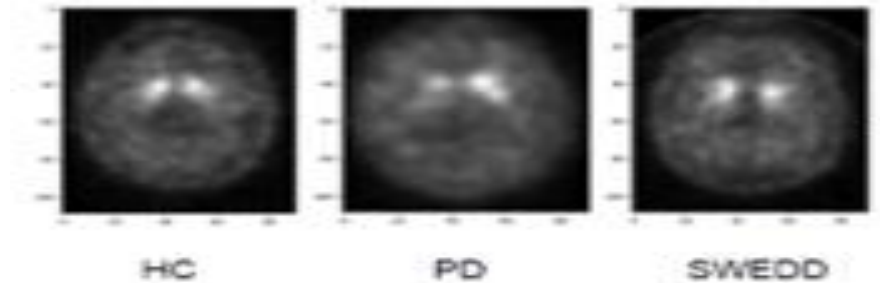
Original PPMI DICOM SPECT images for HC, PD and SWEDD [36]
